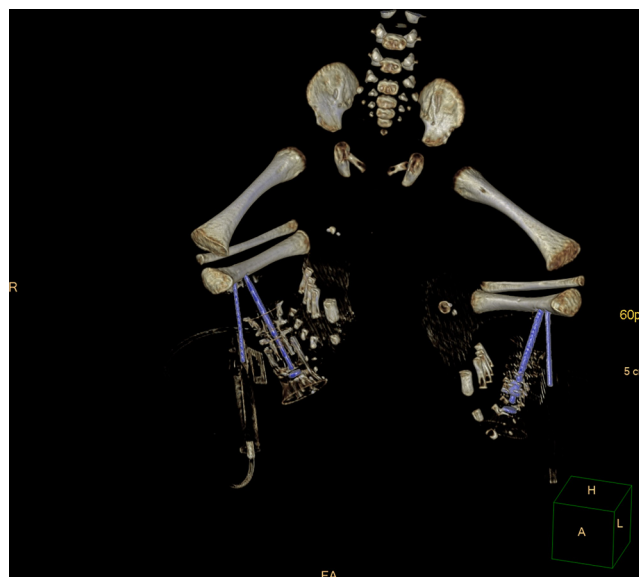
Postmortem computed tomography (CT) of a preterm stillborn infant, age 29 + 1 gestational weeks showing the correct installation of both intraosseous needles on the tibia on both sides (proximal Butterfly needle and distally located hand-twisted EZ-IO® intraosseous needle).
